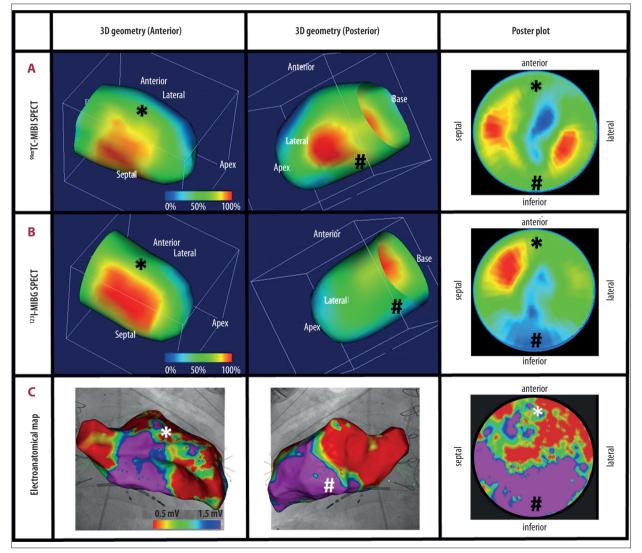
Mismatch between cardiac imaging modalities. (A) Tc-99m-MIBI-SPECT perfusion imaging reveals areas of reduced anterior and inferior perfusion. (B) I-123-MIBG-SPECT imaging demonstrates reduced sympathetic innervation at the inferior left ventricle. (C) Electroanatomical mapping depicts extensive LV anterior scarring as detected by low-voltage areas. area. Substrate-based ablation was performed within the anterior myocardial scarring (low-voltage areas) [2]. Despite abolition of all signals indicating local abnormal ventricular activation, the patient again experienced a VT of midseptal origin (207 bpm, cycle length 290 ms) remote from the myocardial scar, which had to be additionally treated by radiofrequency catheter ablation.
